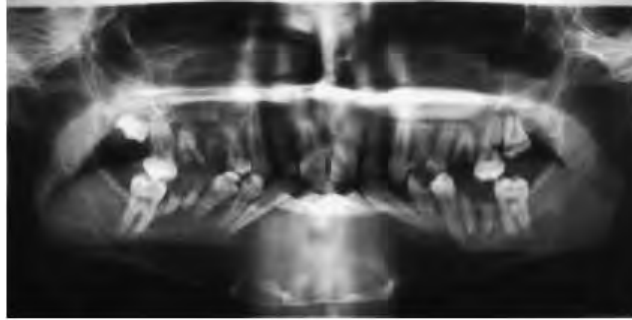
Preoperative orthopantomogram showing large multicystic lesion distending the mandibular body, spanned from second left premolar to second right molar.
